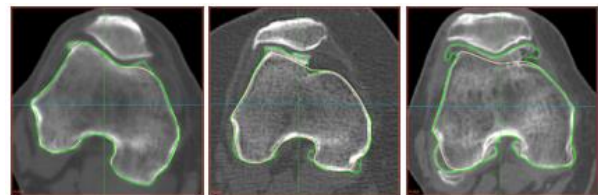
Axial view of CT scans identifying osteophyte formation around the distal femur (green line). From left to right: patient 1 (mild), patient 2 (moderate), and patient 3 (severe).
